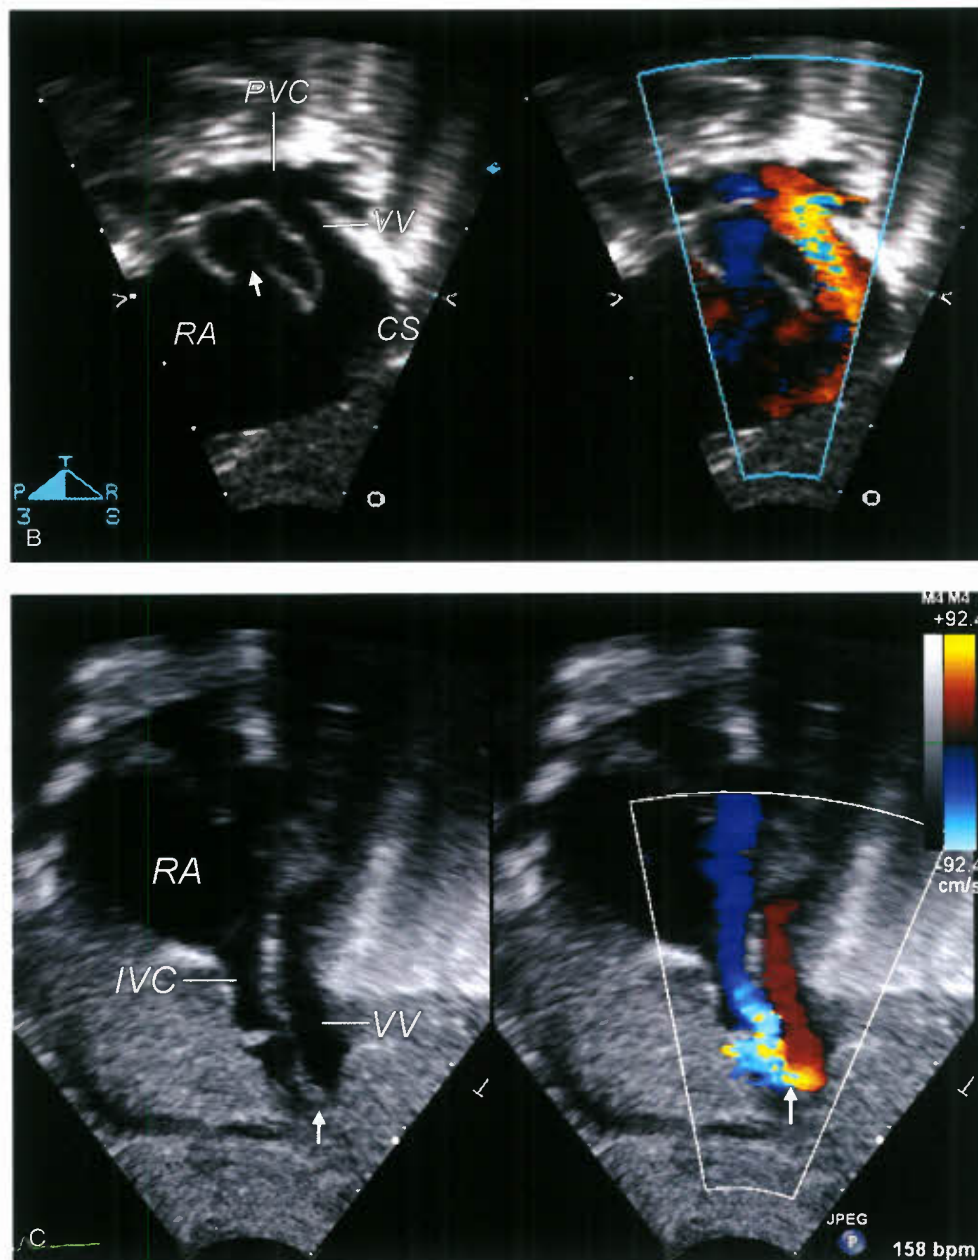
(Continued) B: Subcostal oblique view with color Doppler comparison of TAPVC to the coronary sinus (CS), which is markedly dilated. The image depicts the typical “whale’s tail” appearance of the pulmonary venous confluence (PVC) and connection of the vertical vein (VV) to the CS. Note the obligate right-to-left shunt across the patent foramen ovale (PFO, arrow) and the small left atrium. (RA, right atrium.) C: Subcostal short-axis view with color Doppler comparison of infradiaphragmatic TAPVC in a patient with congenital absence of the left lung. From this view, the descending VV flow is demonstrated (red), with obstruction (arrow) at the point of connection with the IVC.
